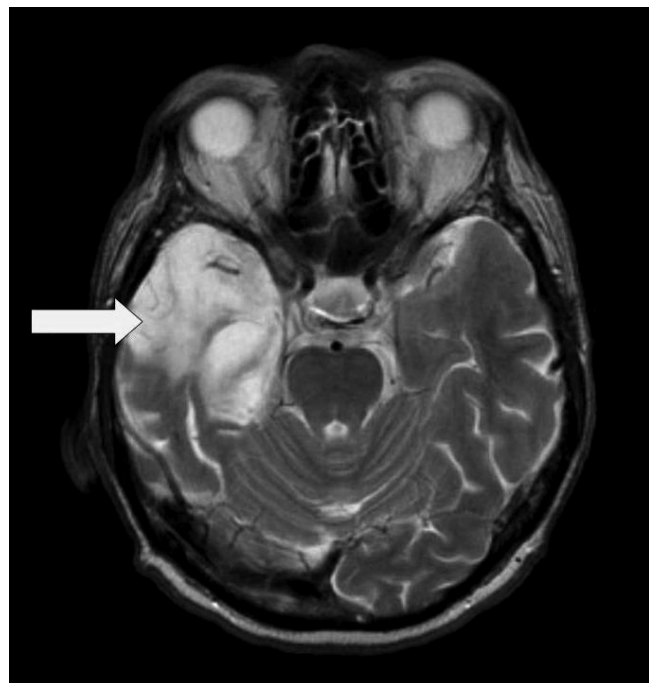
Brain MRI, T2 sequence – significant local atrophy of the right temporal lobe
